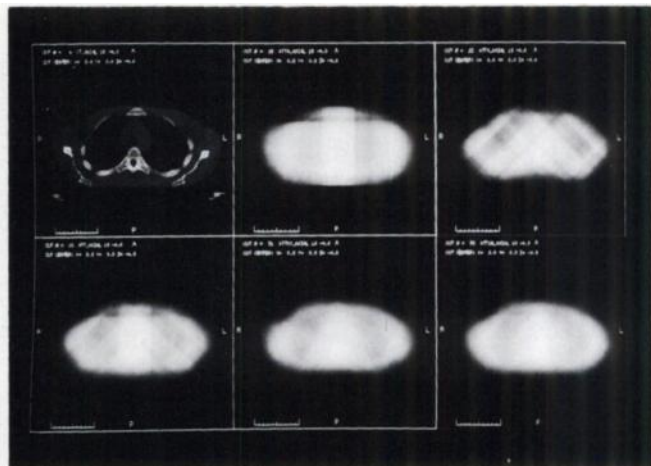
Influence of the number and orientation of the lines used in the calculation of attenuation correction factors,  $f_{att}$ . (A) (upper left): a transaxial CT slice through the thorax. (B–F) show the same slice, but here the grey-level reflects the magnitude of  $f_{att}$ . (B) (upper middle):  $f_{att}$  calculated using lines in four directions: up, down, left and right. (C) (upper right): four lines, diagonal directions. (D) (lower left): eight lines, directions of B and C combined. (E) (lower middle): eight lines, directions at intermediate angles. (F) (lower right): 16 lines, directions of D and E combined.
